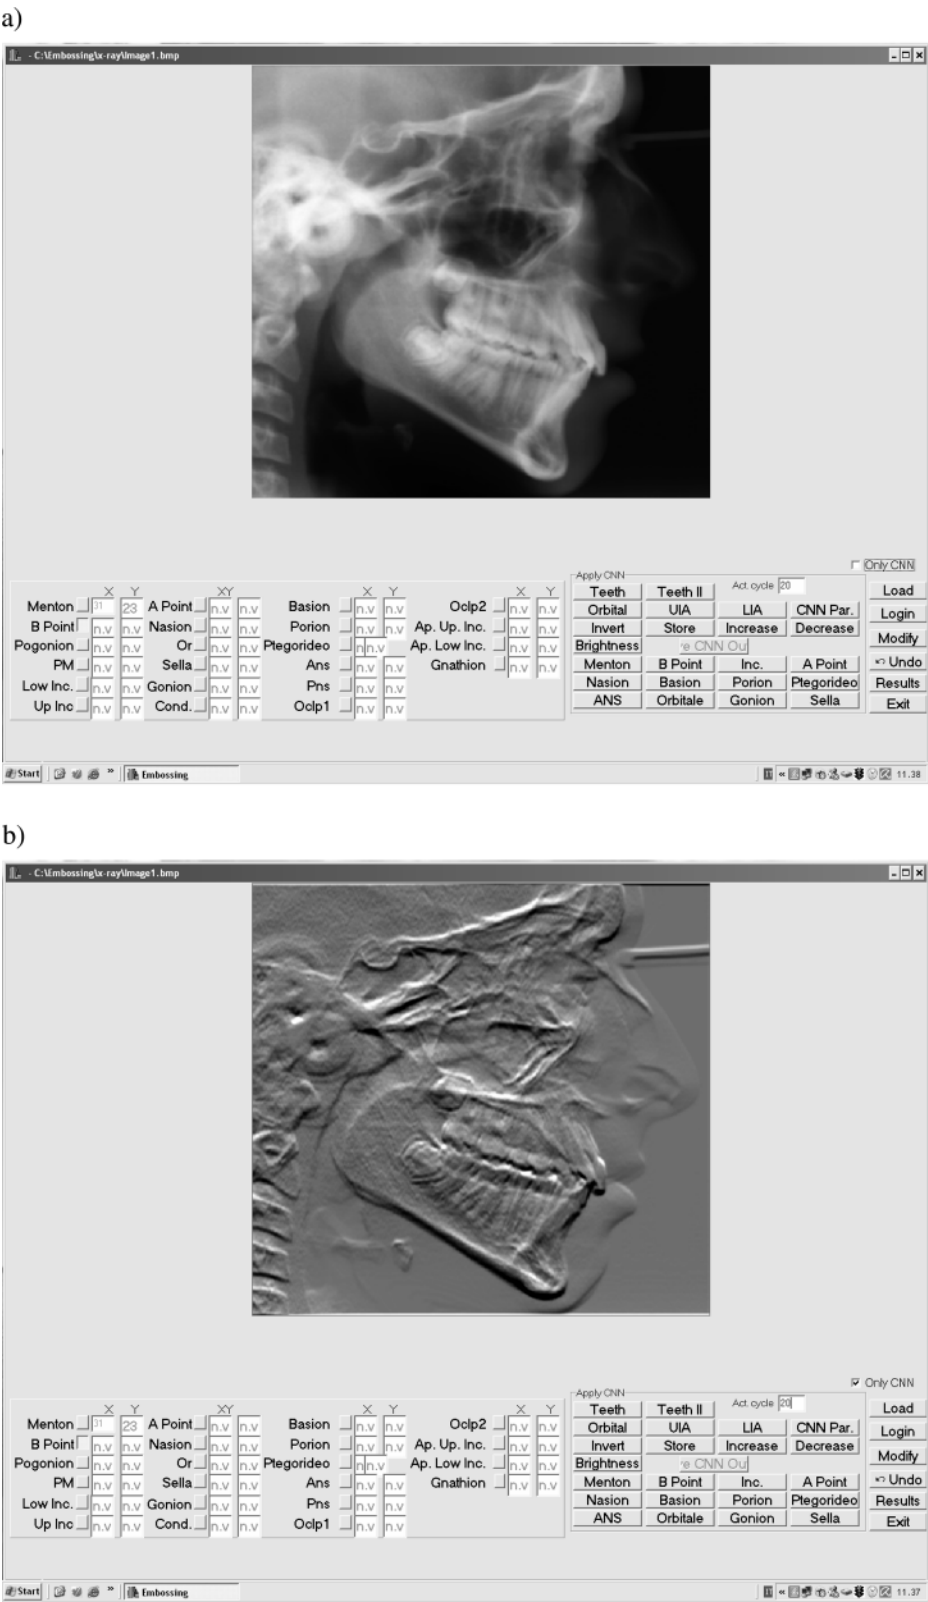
The interface of the landmarking tool: (a) an unfiltered and (b) an embossed radiograph.
